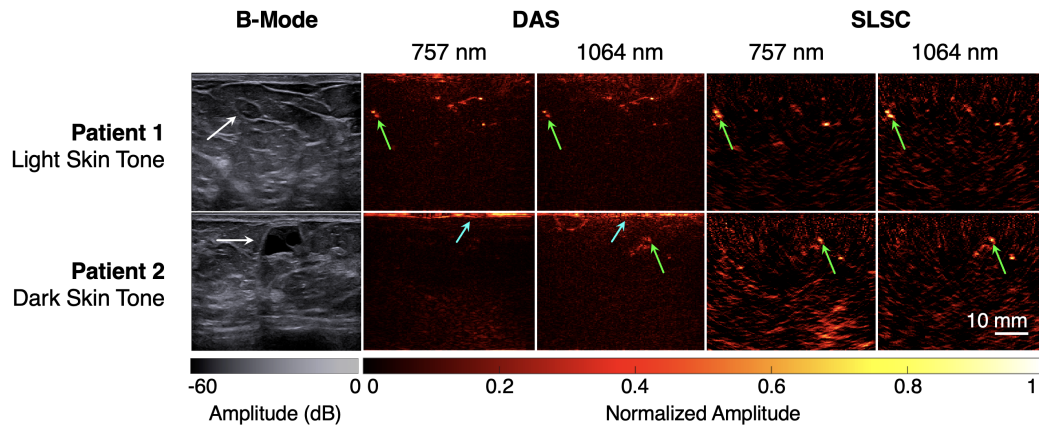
Ultrasound and corresponding photoacoustic images of *in vivo* targets underlying light ( $ITA = 71^\circ$ ) and dark ( $ITA = -72^\circ$ ) skin tones. White, blue, and green arrows indicate benign, shallow (i.e.,  $<5$  mm), and deep (i.e.,  $\geq 5$  mm) structures, respectively.
